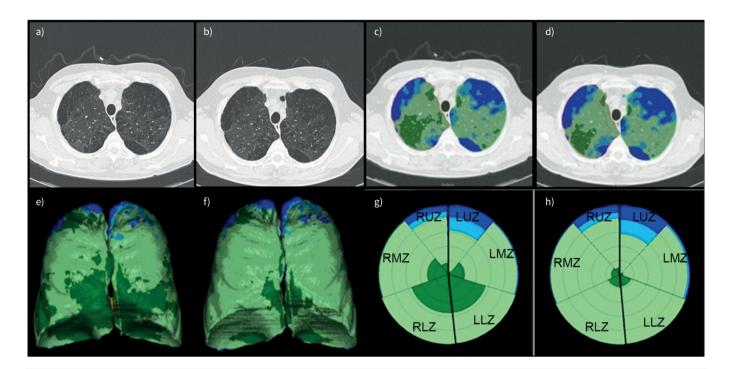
Computer-Aided Lung Informatics for Pathology Evaluation and Rating (CALIPER) analysis of computed tomography (CT) scans at baseline (T1) and follow-up (T3). Axial CT images at a) T1 and b) T3 and CALIPER-derived colour image overlays at c) T1 and d) T3. Three-dimensional CALIPER coronal rendering of the lungs at e) T1 and f) T3 displaying different parenchymal patterns (colour-coded). In g) and h) the glyphs provide summary of distribution for CT patterns in lung parenchyma at T1 and T3 in various colours (dark green: normal lung; light green: mild low-attenuation areas (LAAs); light blue: moderate LAAs; dark blue: severe LAAs). All, mild, moderate and severe LAAs increased from 65.2%, 58.4%, 3.4% and 3.4%, respectively, at T1 to 88.5%, 80%, 4.1% and 4.4%, respectively, at T3. LLZ: left lower zone; LMZ: left middle zone; LUZ: left upper zone; RLZ: right lower zone; RMZ: right middle zone; RUZ: right upper zone.
